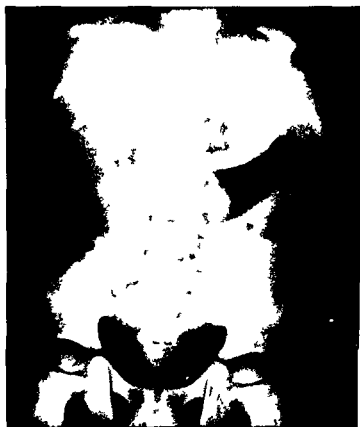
Plain radiograph of an abdomen in a case of intussusception in an infant showing the caput of the intussusception outlined against gas in the colon distal to it.
